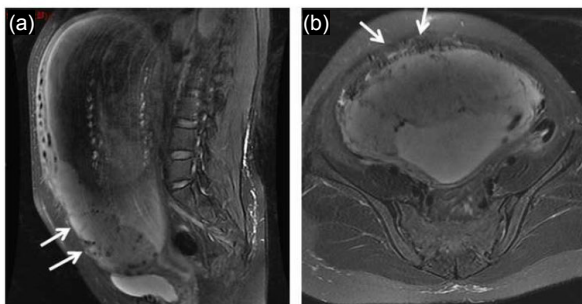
Magnetic resonance imaging (MRI) at 30 weeks of gestation demonstrating an irregular border between the myometrium and placenta (arrows)
